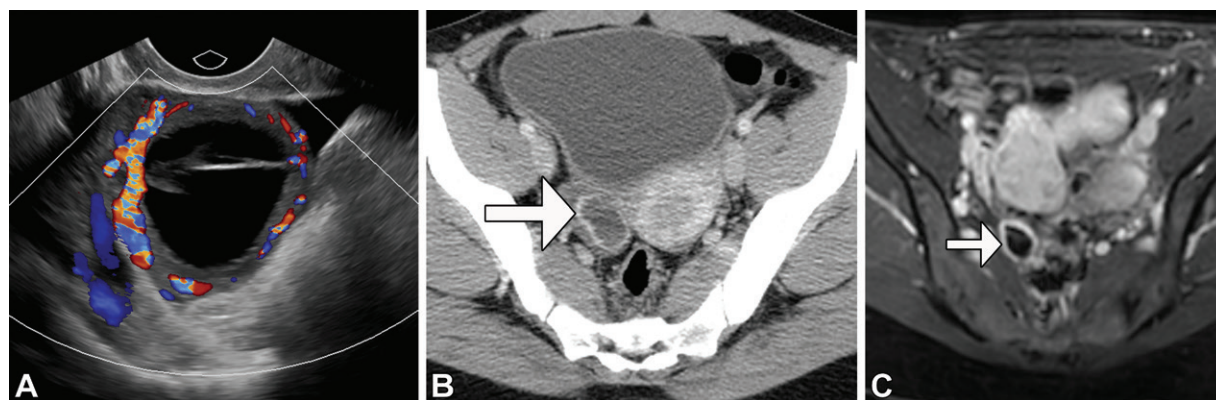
Normal appearance of the corpus luteum in three different patients. (A) Color Doppler US image shows a 2.6-cm cystic corpus luteum with peripheral vascularity. (B) Axial contrast-enhanced CT image shows a 2.4-cm rim-enhancing corpus luteum (arrow) in the right ovary. (C) Axial contrast-enhanced T1-weighted fat-suppressed MR image shows a similar 2.1-cm rim-enhancing corpus luteum (arrow) in the right ovary.
